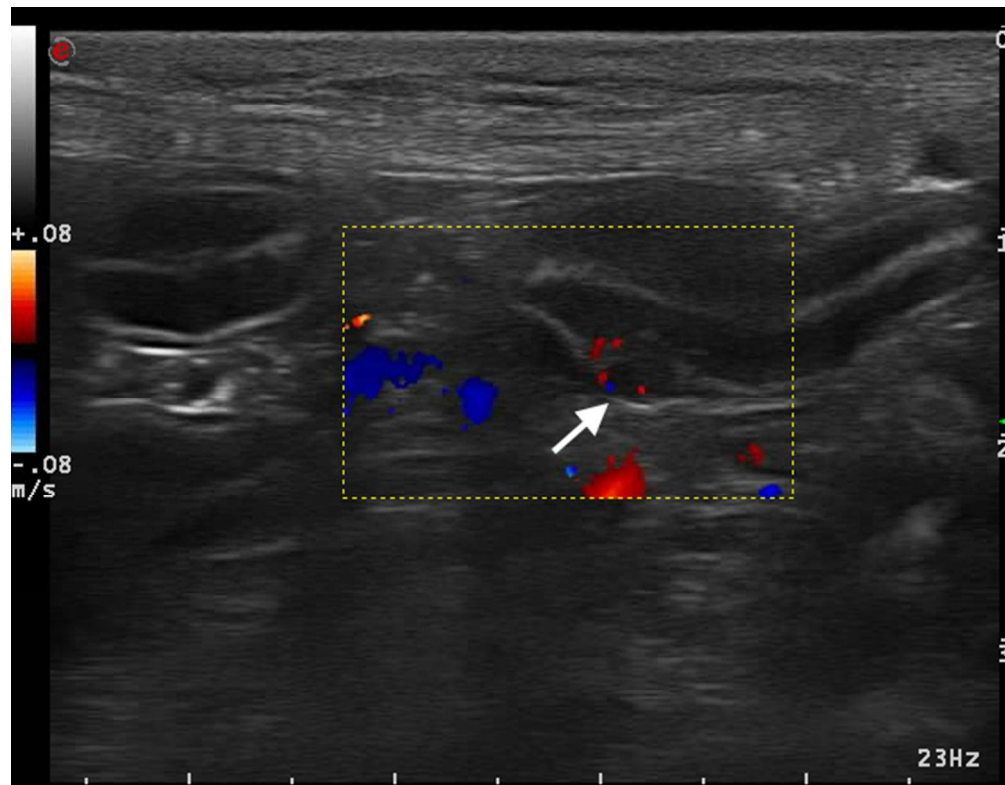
Color Doppler image of another segment of the distal jejunum. A well-marginated hypoechoic nodule is present in the muscularis layer of the intestinal wall. No abnormal flow signal was detected inside the nodular lesion as in the rest of the intestinal wall.
